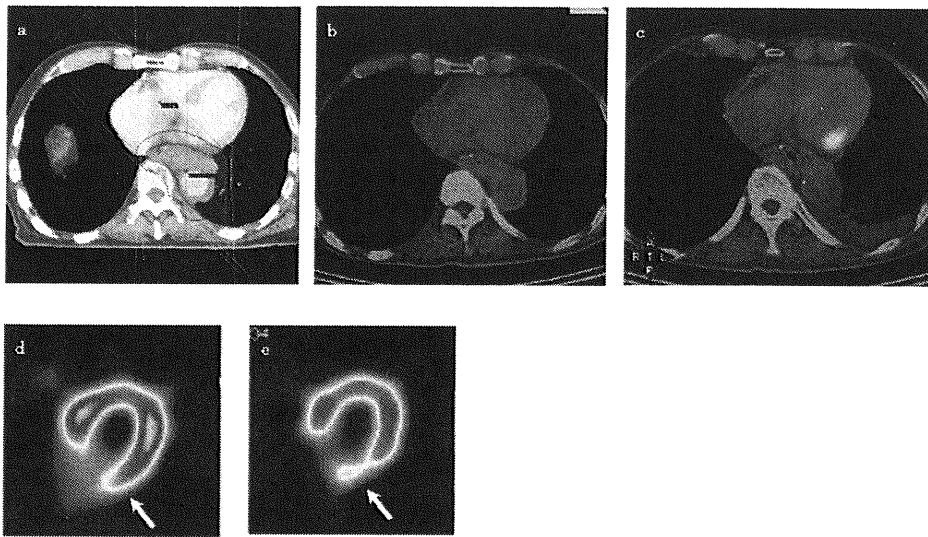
Images of Patient 7 (78-year-old male) after chemoradiotherapy for postoperative recurrent esophageal cancer. (a) Dose-distribution axial image. (b) F-fluorodeoxyglucose-positron emission tomography/computed tomography (FDG-PET/CT) axial image one month after chemoradiotherapy. (c) FDG-PET/CT axial image five months after chemoradiotherapy. (d)  $^{123}\text{I}$ -BMIPP axial image. (e)  $^{201}\text{TlCl}$  axial image. FDG-PET/CT did not show abnormal FDG accumulation at one month after chemoradiotherapy but clearly showed high FDG accumulation in the high-dose irradiated myocardium at five months after chemoradiotherapy.  $^{123}\text{I}$ -BMIPP and  $^{201}\text{TlCl}$  uptake are decreased markedly in the region (arrows).
